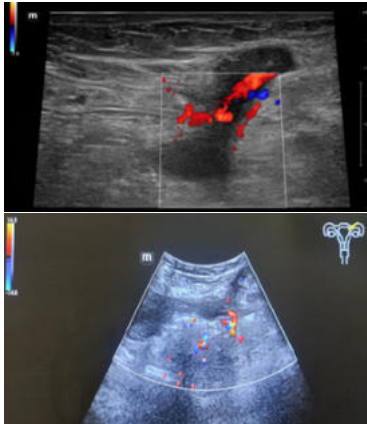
Ultrasound of left adnexa demonstrate a fallopian tube showing normal vascularity adhered to the scar site.
